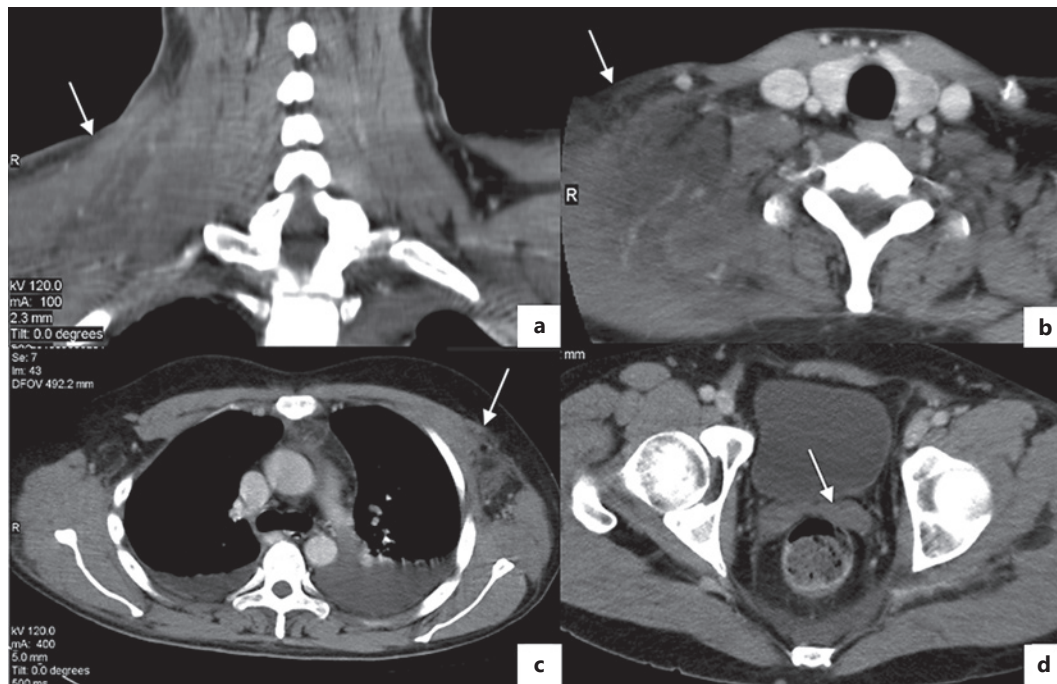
Body CT showing inflammatory signs: right supraclavicular area (a, b); mediastinal and left axillary areas (c); pelvic area (d).
